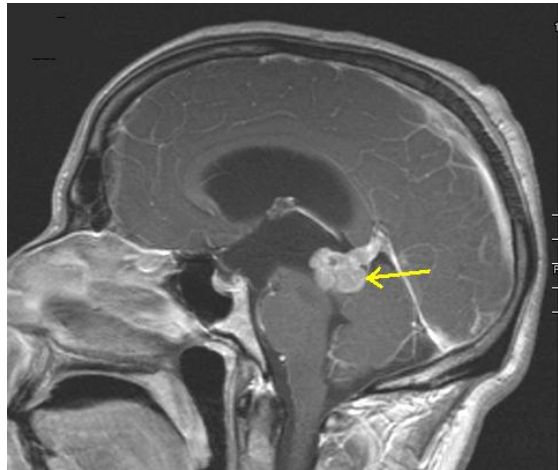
Low grade astrocytoma of the midbrain (lamina tecti). Sagittal T1-weighted magnetic resonance imaging. The tumor is marked with an arrow.
